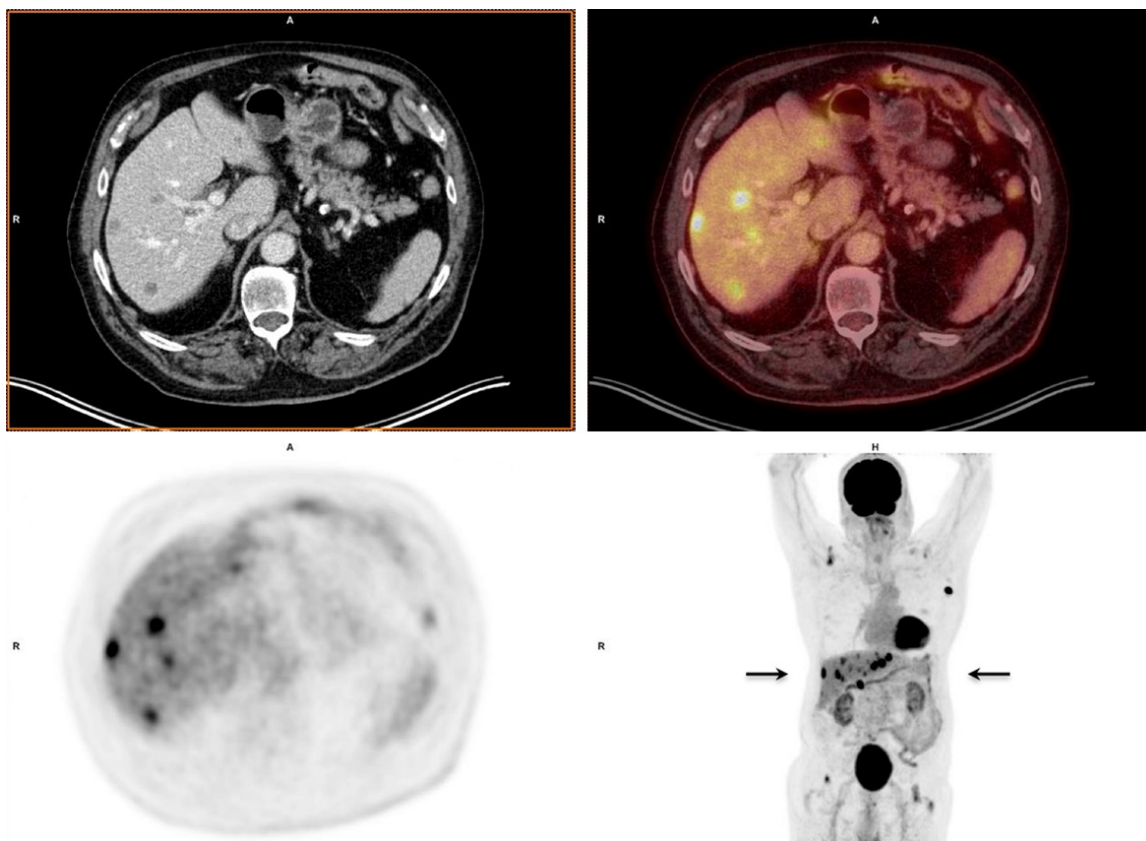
A 65-year old male with distant metastasis seen on PET/CT. This patient is diagnosed with a pT4a MCM frontotemporal. Pathological positive lymph nodes preauricular were observed. PET/CT revealed lymphatic and hepatic metastasis.
